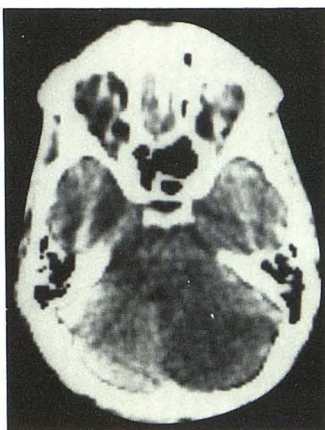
Case 14. Noncontrast CT. A, Small area of low density in right cerebellum, intact fourth ventricle and cisterns, and absence of temporal horn dilatation. B, Repeat scan. Larger area of hypodensity in right cerebellum, displacement of fourth ventricle to left, and dilatation of right temporal horn.
